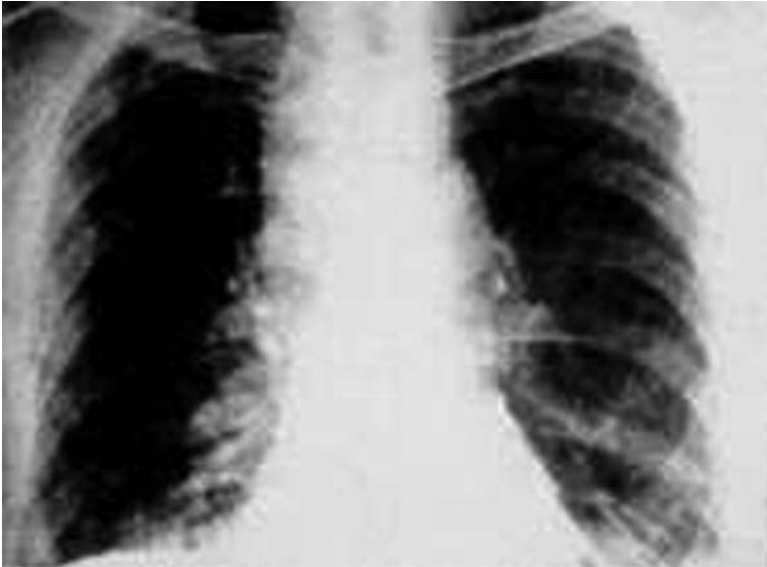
Chest X-ray of inhalational anthrax, demonstrating marked mediastinal widening and a small parenchymal infiltrate. (Reprinted, with permission, from ref. 6.)
